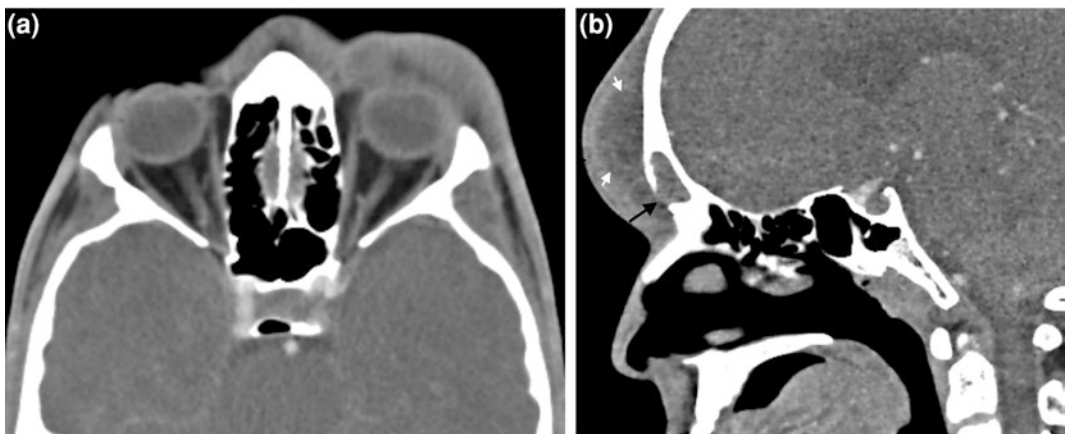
Frontal sinusitis complicated by frontal osteomyelitis and Pott Puffy tumour. a–b Axial and sagittal reformatted contrast-enhanced CT images reveal opacified left frontal sinus with small defect at its anterior wall due to osteomyelitis (arrow). There is large periorbital cellulitis and extracranial abscess with an enhancing rim (arrow heads), a finding suggestive of a Pott puffy tumor. No evidence of intracranial abscess formation
